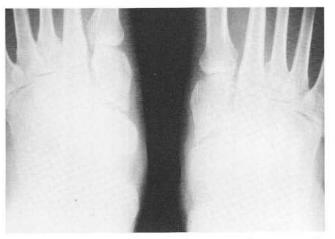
Weight bearing x-rays of a patient with a calcaneonavicular bar and pes cavus deformity.
